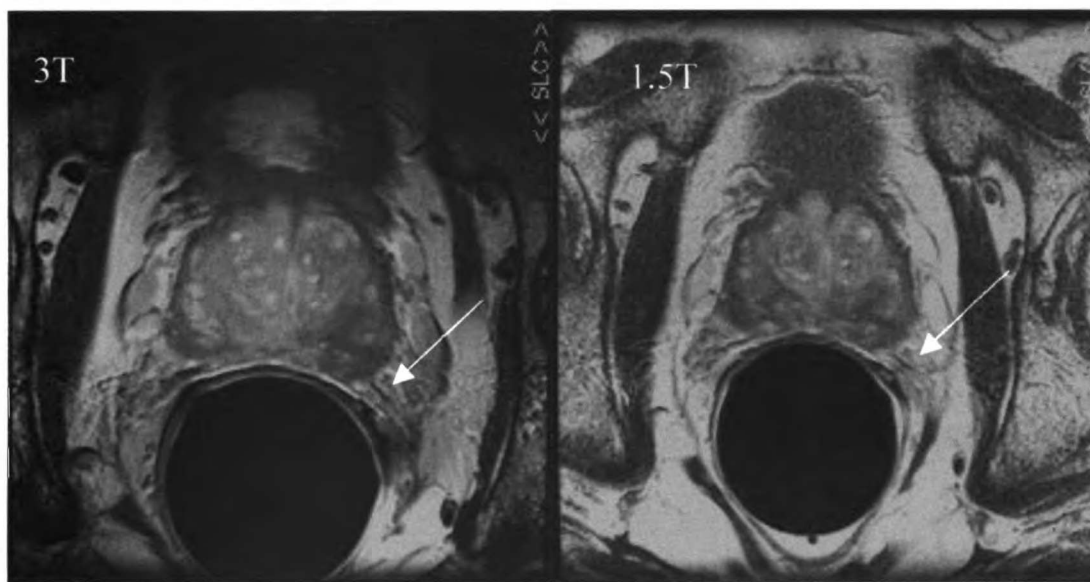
Prostate cancer patient imaged at both 3T and 1.5T using Medrad endorectal coil. Oblique axial T2-weighted FSE images acquired at 3T in 3:42 using 256x192 encoding matrix, 6000s/102ms TR/TE, 3mm thick slices and 12 cm FOV (14 cm for 1.5T). Improved image quality was observed at 3T. Finer structures such as the neurovascular bundles (arrow) were better depicted at 3T due to higher spatial resolution and increased susceptibility weighting.
